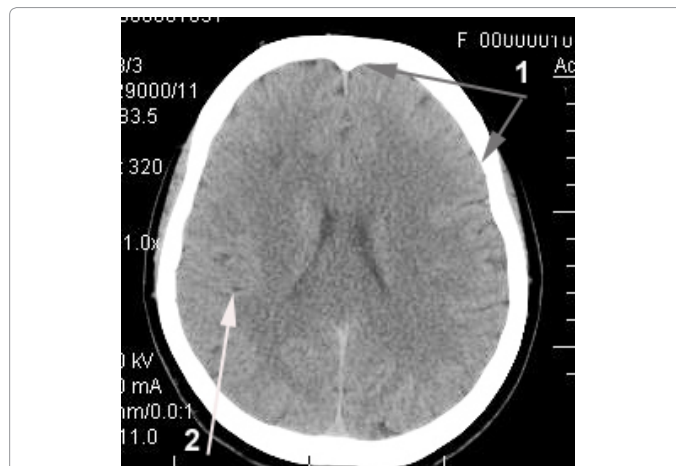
Same patient H.: CT of the brain. 12 Months after the Intervention: 1) subarachnoid space restoration, 2) reduction in the size of the post-ischemic cyst with signs of cerebral tissue structure recovery.
